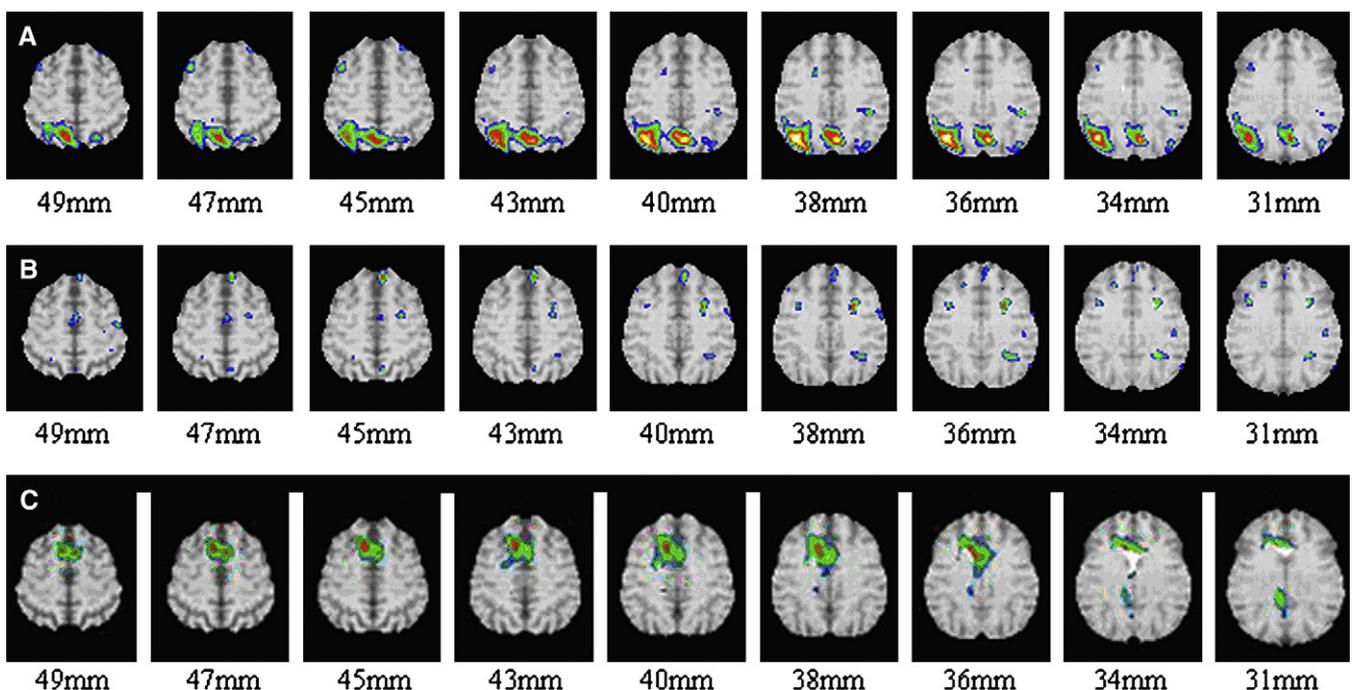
Examples of ¹⁸FDG-PET difference images between different individual MCI patients versus controls showing examples of presence (A) and absence (B) of an AD-like pattern as well as one with an FTD pattern (C). The numbers indicate millimeters above the anterior and posterior commissural plane. Orientation is same as in Fig. 1.
